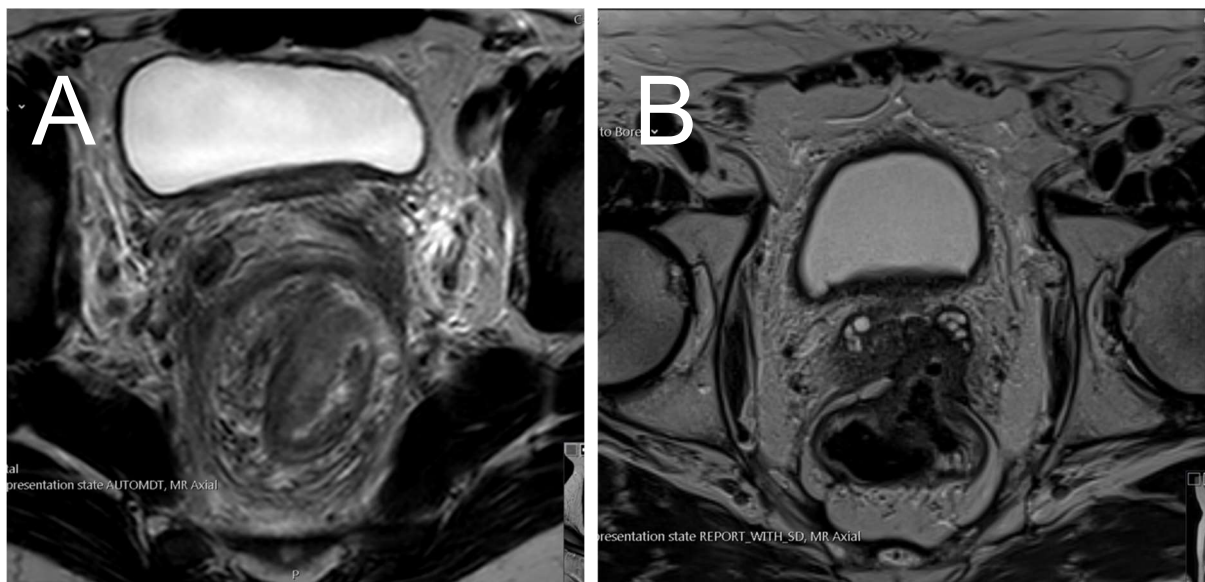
(A) Poor resolution T2 weighted axial MRI image which is sub-optimal for operative planning. (B) High resolution better quality image.
